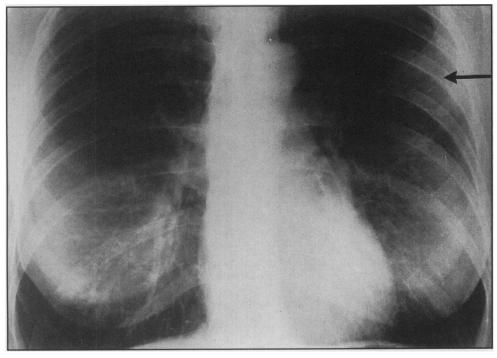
Chest X-ray showing an opacity in the left upper lobe initially suggestive of a primary lung tumour.
